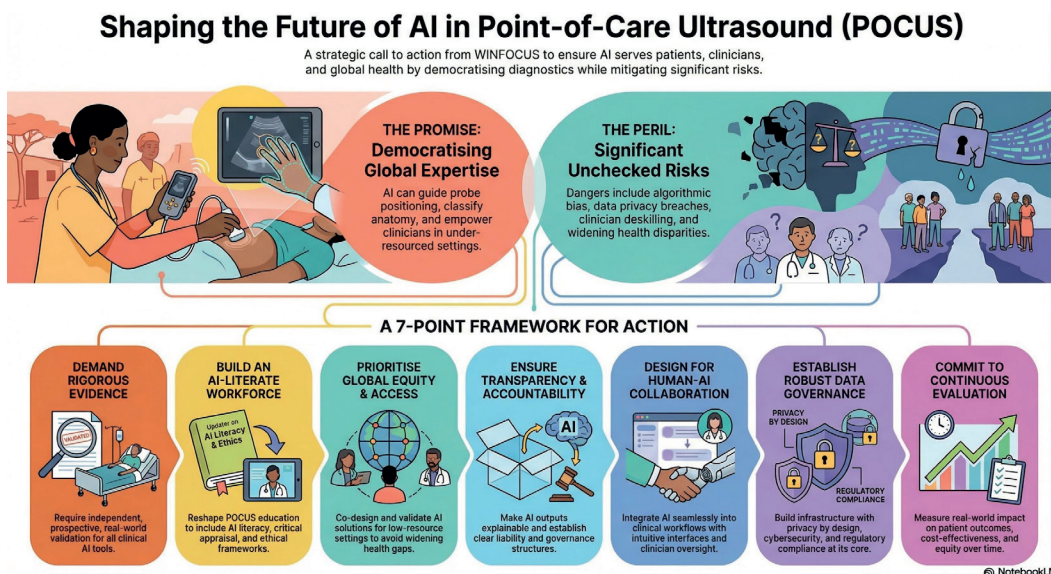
Shaping the future of AI in Point-of-Care Ultrasound (POCUS).
